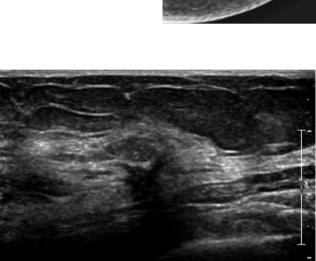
Ultrasonography targeted at 3 o'clock in the breast revealed a hypoechoic lesion (Used with permission from Andrejeva et al. [103])
